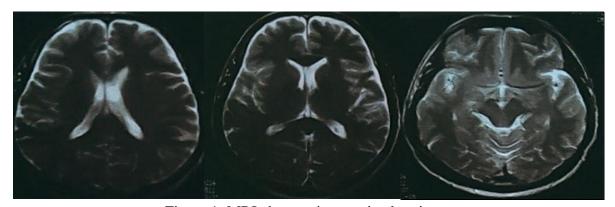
MRI changes in examined patients.
